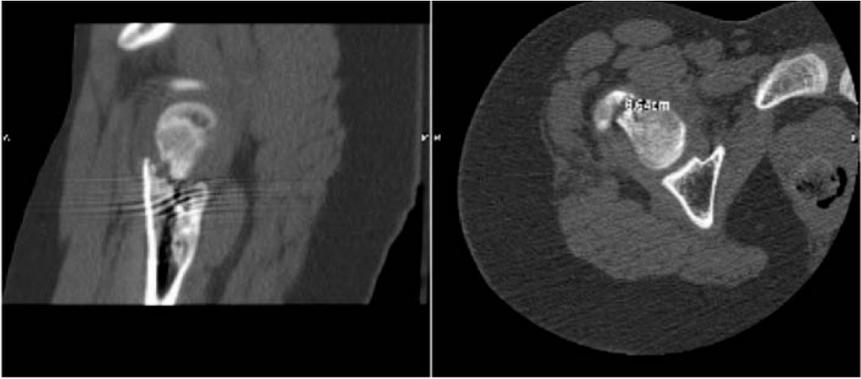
Computer Tomography (CT) slices demonstrating the same fracture as shown in Figure 7.
